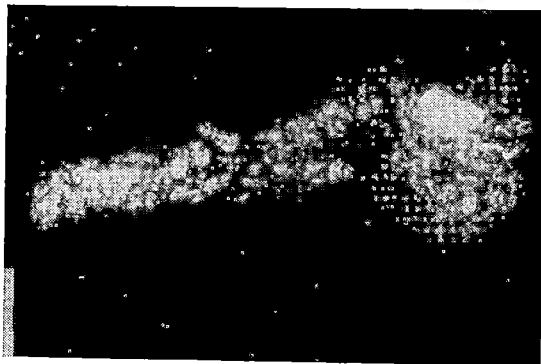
Post mortem X-ray of the pancreas showing extensive calcification of the pancreas in patient 5.
